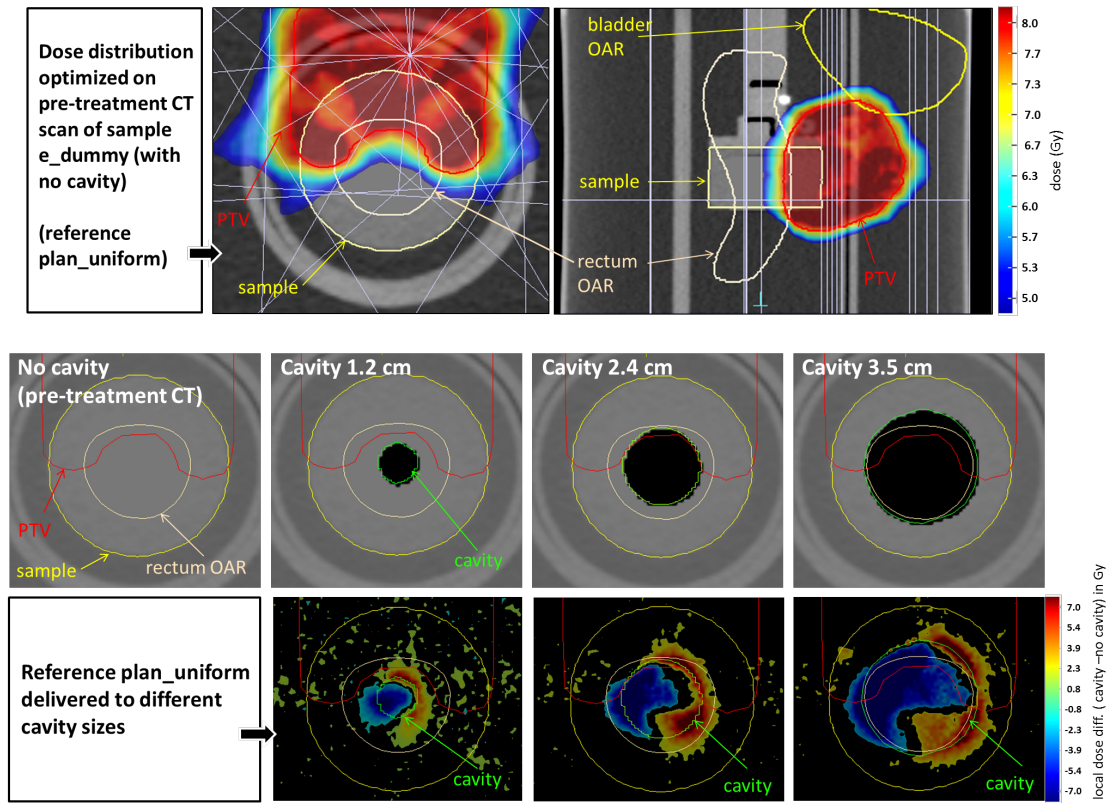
Optimized dose distribution calculated on the pre-treatment CT scan (no cavity) is shown on the top panel. On the bottom panel, the pre-treatment CT scan is again shown displaying a situation of a homogeneous PRESAGE® sample (no cavity) and with three different cavity sizes. The PTV and the rectum contours are shown for reference. The density on the CT scan was overridden based on the defined contours shown in green. The contour of the PRESAGE® sample is also shown (yellow). Local dose differences between the dose distribution obtained by delivering the reference plan_uniform to a homogeneous PRESAGE®, and to three different cavity sizes are displayed. A more extensive and higher difference in dose is visible for a 3.5cm diameter cavity.
